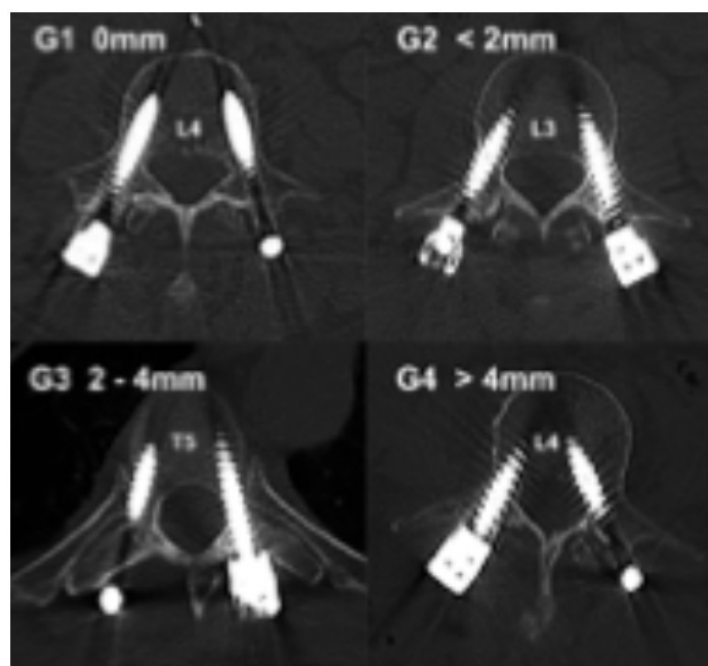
Gertzbein & Robbins CT classification [11]. Grade 1 (0mm), Grade 2 (<2mm), Grade 3 (2-4mm), and Grade 4 (>4mm).
